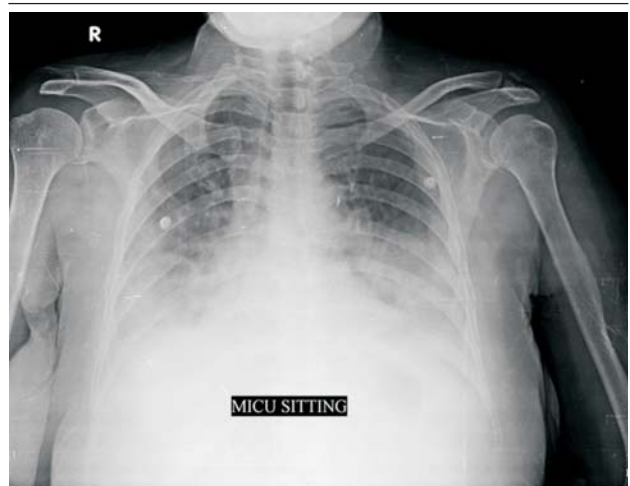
Chest X-ray on day 5 of hospitalisation showing bilateral interstitial pneumonia.
